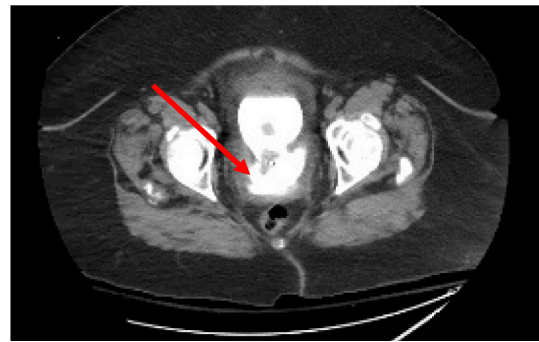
CT Cystogram demonstrating extravasation of contrast from the urinary bladder into the adjacent soft tissues.
